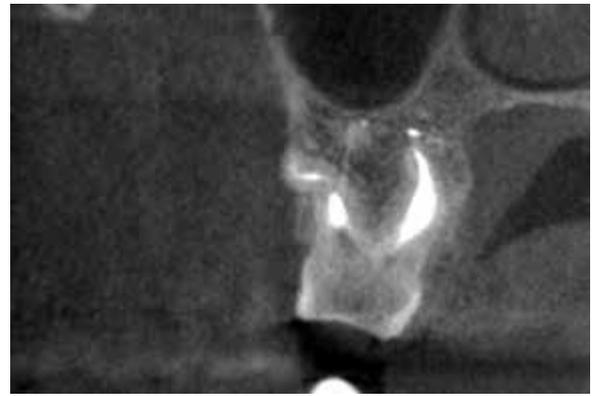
CB-CT images showing how the S-shaped anatomy of DB root has been entirely cleaned, shaped (with Ni-Ti rotary instruments used in manual rotation), then filled.
